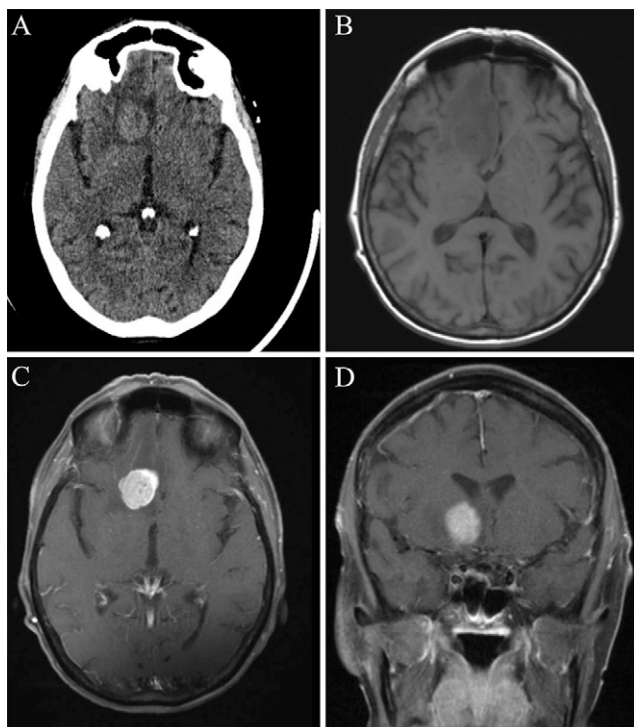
A: Noncontrast CT shows a hyperdense inferior parasagittal right frontal lobe mass with surrounding hypodense edema. B: Axial T1-weighted MRI sequence shows a T1 isointense mass with surrounding edema. Postcontrast axial (C) and coronal (D) T1-weighted MRI sequences depict avid enhancement of the mass.
